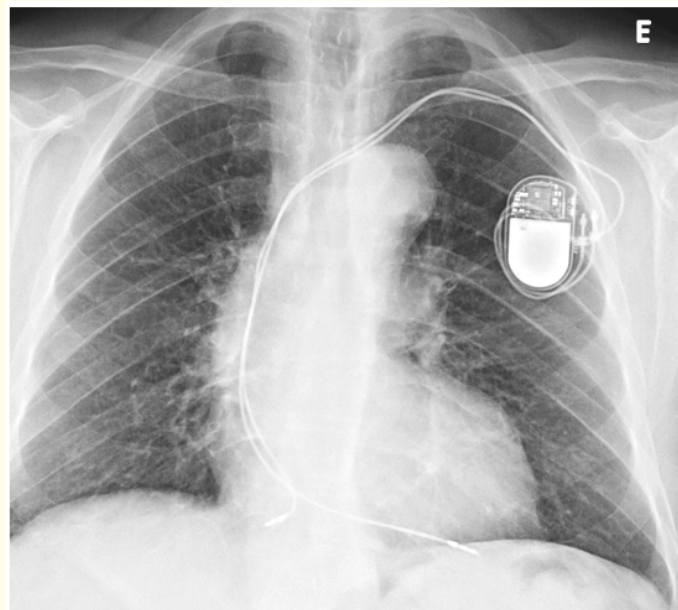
Thorax radiography.
